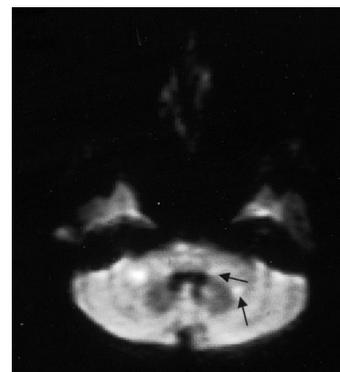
Diffusion axial MRI scan showing new ischemic changes (arrows).
